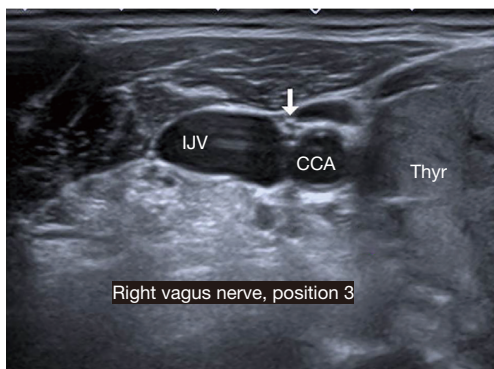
Ultrasound aspect of the right vagus nerve (white arrow) in position 3. THYR, thyroid lobe; IJV, internal jugular vein; CCA, common carotid artery.
